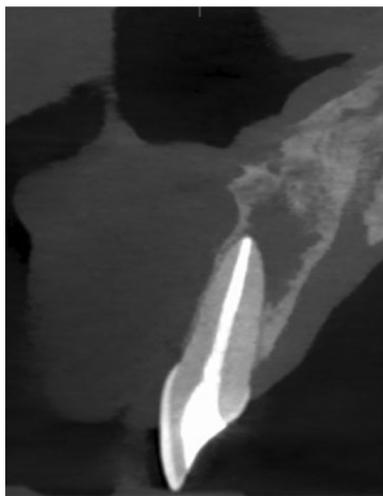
Sagittal slice of CBCT of Tooth #8 9 months after decompression device removed showing osseous deposition and reduction in size of radiolucency.
